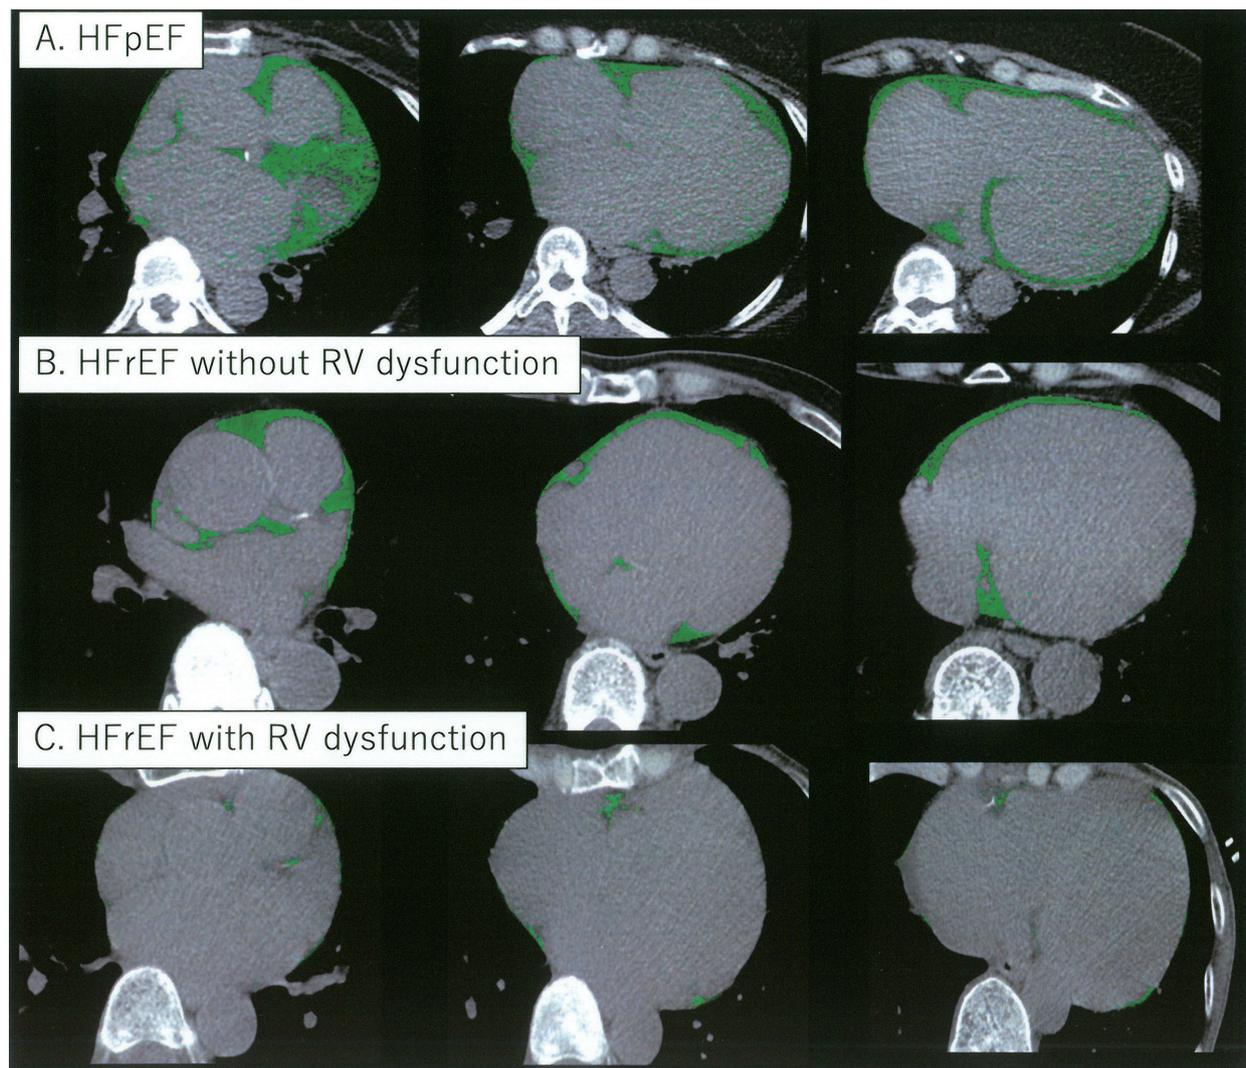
CT showing EAT in representative cases of HFpEF, HFReEF without RV dysfunction, and HFReEF with RVD. (A) CT showing abundant EAT surrounding the heart in a patient with HFpEF. (B) CT showing intermediate amount of EAT surrounding the heart in a patient with HFReEF without RVD. (C) CT showing very little EAT surrounding the heart in a patient with HFReEF with RVD. CT, computed tomography; EAT, epicardial adipose tissue; HFpEF, heart failure with preserved ejection fraction; HFReEF, heart failure with reduced ejection fraction; and RVD, right ventricular dysfunction.
